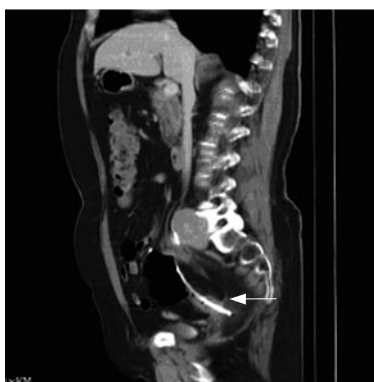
CT-scan of colonic perforation caused by migrated biliary endoprosthesis. Arrow marks dislocated stent.
